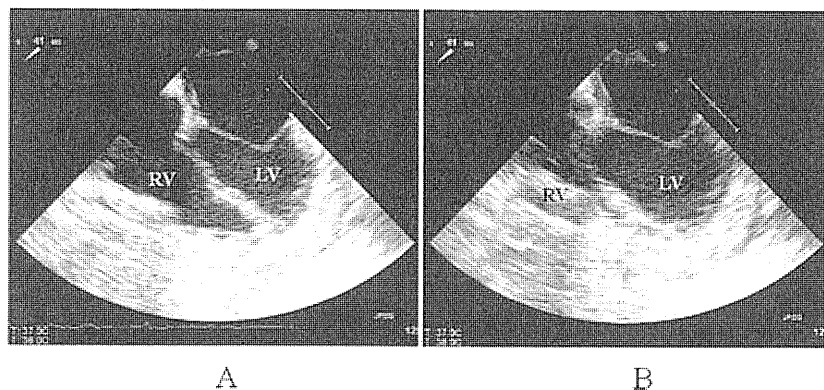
Intraoperative transesophageal echocardiographic study (A) while the patient was on cardiopulmonary bypass and before biventricular assist device (BiVAD) support was started and (B) on BiVAD support (Jarvik 2000 RVAD: dial 1, DuraHeart LVAD: 1600 rpm). On starting the BiVAD, the interventricular septum shifted immediately to the right side and sucking of the right ventricular (RV) wall by the Jarvik 2000 was observed. LV, left ventricle.
